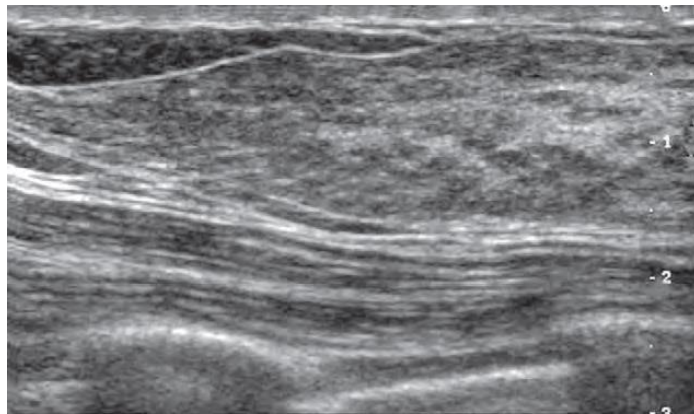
Normal sonographic appearance of the breast.(Rumack-2011)
